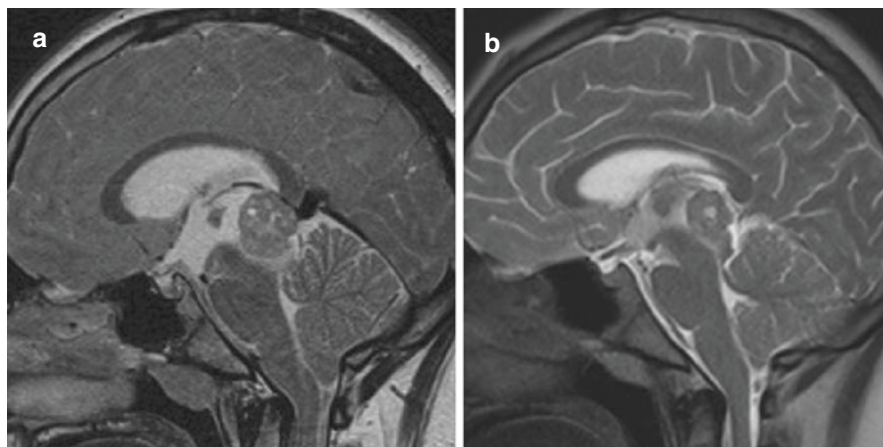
Sagittal T2-weighted MR of pineal germinoma before (a) and after (b) a 3-day use of dexamethasone therapy. There is a marked reduction of the tumor mass together with decreased hydrocephalus and degree of tonsillar ectopia
